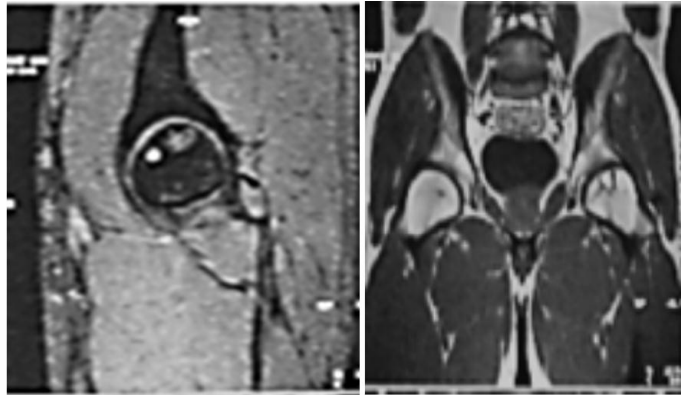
MRI scans of the same patient (left hip). Subchondral cystic lesions and sclerosis, T1 and T2 weighted scans.
